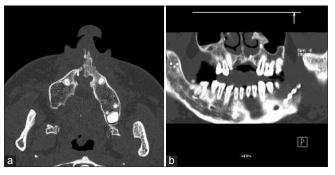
(a and b) Radiographic assessment at 2006 of the previously grafted alveolar clefts. Note the narrow width of the alveolar ridge, especially in the right anterior maxilla, which is not suitable to accommodate dental implants
